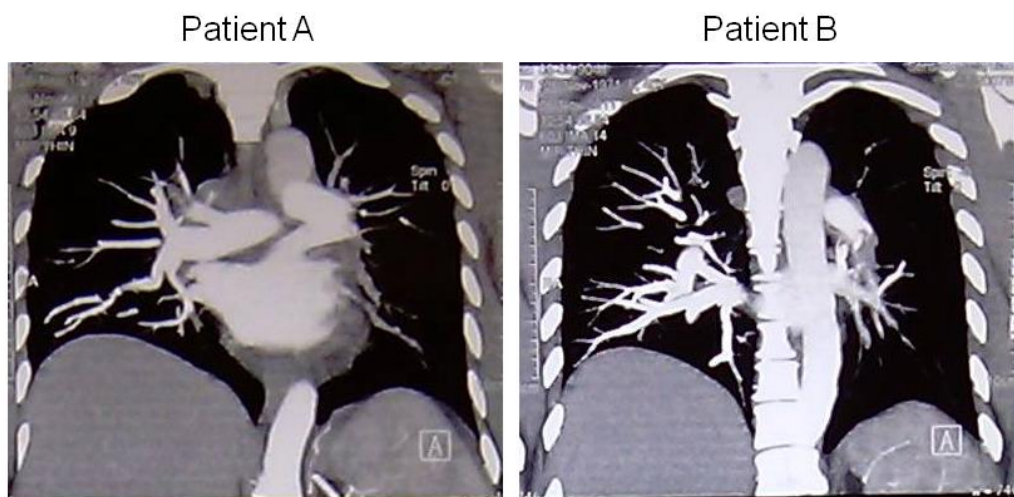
CT angiogram in both patients is depicted in this figure. Patient A: a large filling defect is seen in left pulmonary artery, which extends to its basal branches of lower lobe artery. Patient B: Filling defect in left apical pulmonary artery branches of apical and upper lobe artery. Findings in both patients are indicative of large pulmonary emboli involving the left lung.
